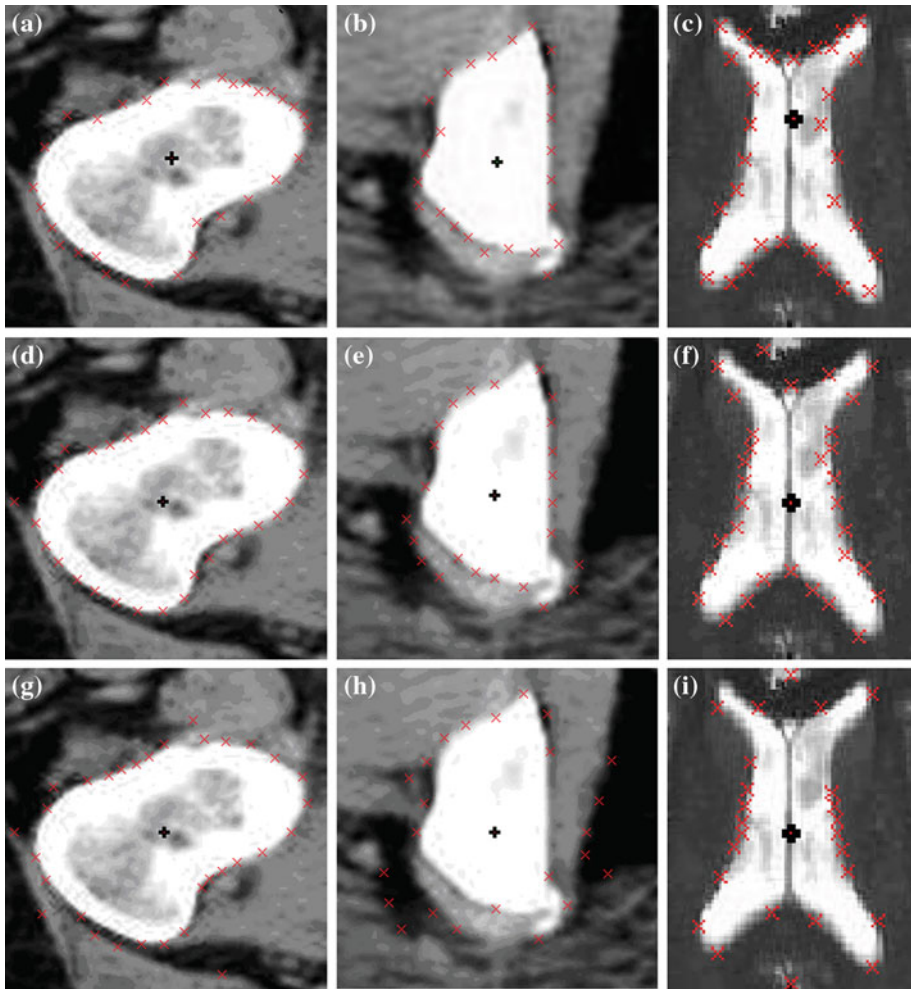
The experimental results of the initial boundary point selection for the three ROIs from real CT and MR image of Fig 13. The *upper row a–c* shows the results of the IBPS for the three ROIs. The *middle row d–f* is the results of ISSM. The *bottom row g–i* is the results of Yuen et al.
